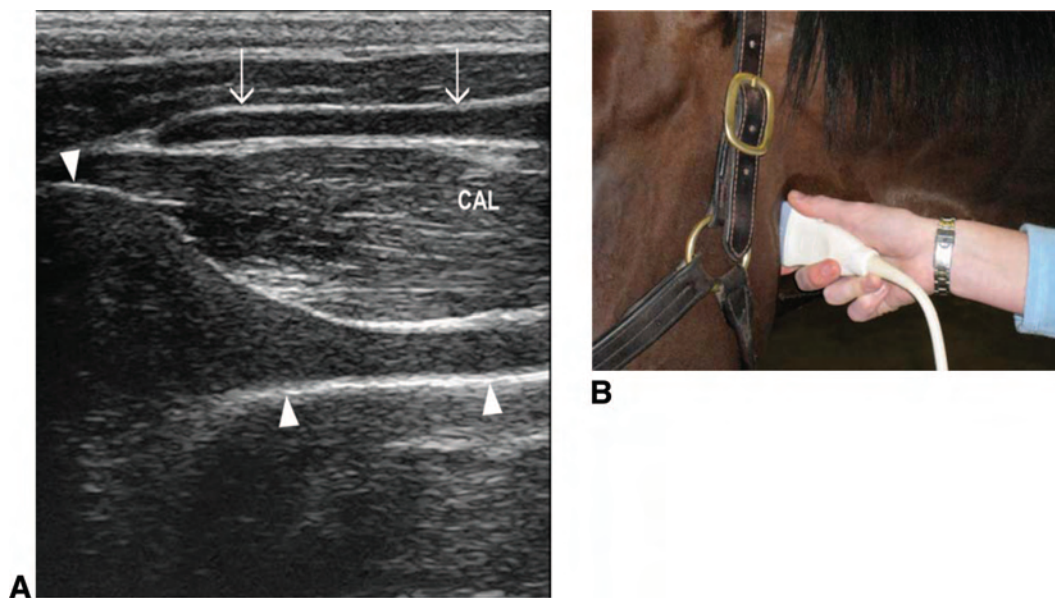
Transverse plane ultrasound image of the lateral aspect of a normal larynx (A). Transducer position is shown in B. Note the position of the cricoarytenoid lateralis muscle (CAL) between the thyroid cartilage (arrows) and the arytenoid cartilage (arrowheads). The arytenoid cartilage has a trumpet bell shape and the cricoarytenoid lateralis muscle has a striated appearance with heterogeneous echogenicity. Dorsal is to the left of the image and ventral is to the right of the image.
